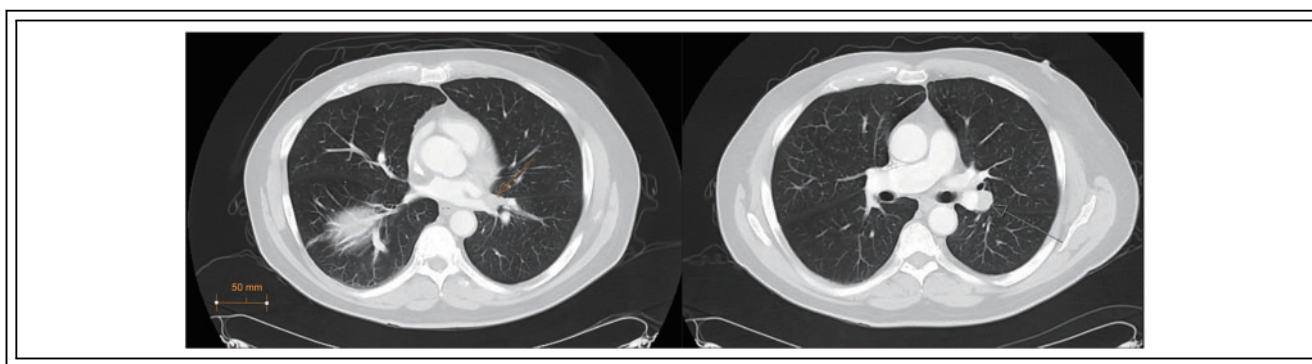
Left hilar lesions, CT Chest (axial, lung window) (7/14/2023)
